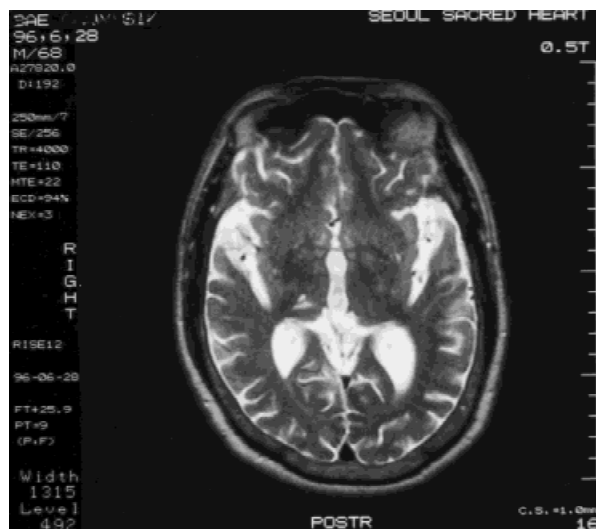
Axial T2-weighted brain MRI scan of case 2 shows high signal-intensity lesions confined to the right posterolateral thalamus.
